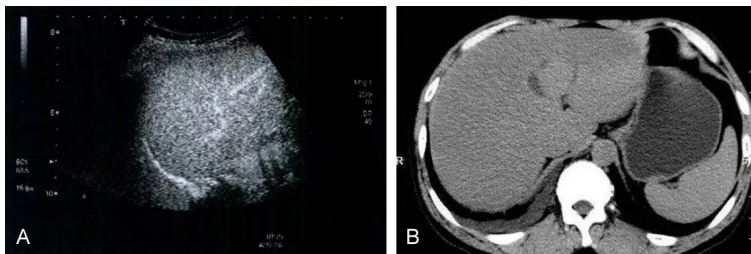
Representative liver Doppler and abdominal CT images of patient with MASLD. A: Color Doppler images; B: Liver CT images. Notes: MASLD, metabolic dysfunction-associated fatty liver disease.
